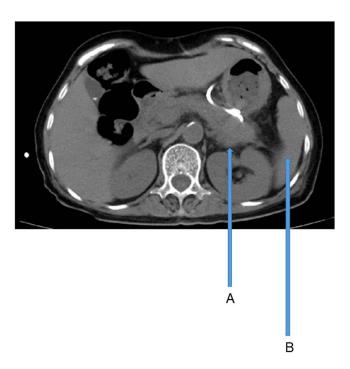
Abdominal CT scan at the time of discharge for this case. (A) The pancreas demonstrates an enlarged morphology with heterogeneous internal density. There are patchy areas of slightly lower density with indistinct borders. A local drainage tube has been implanted. (B) The spleen appears normal, with no apparent abnormalities in density.
